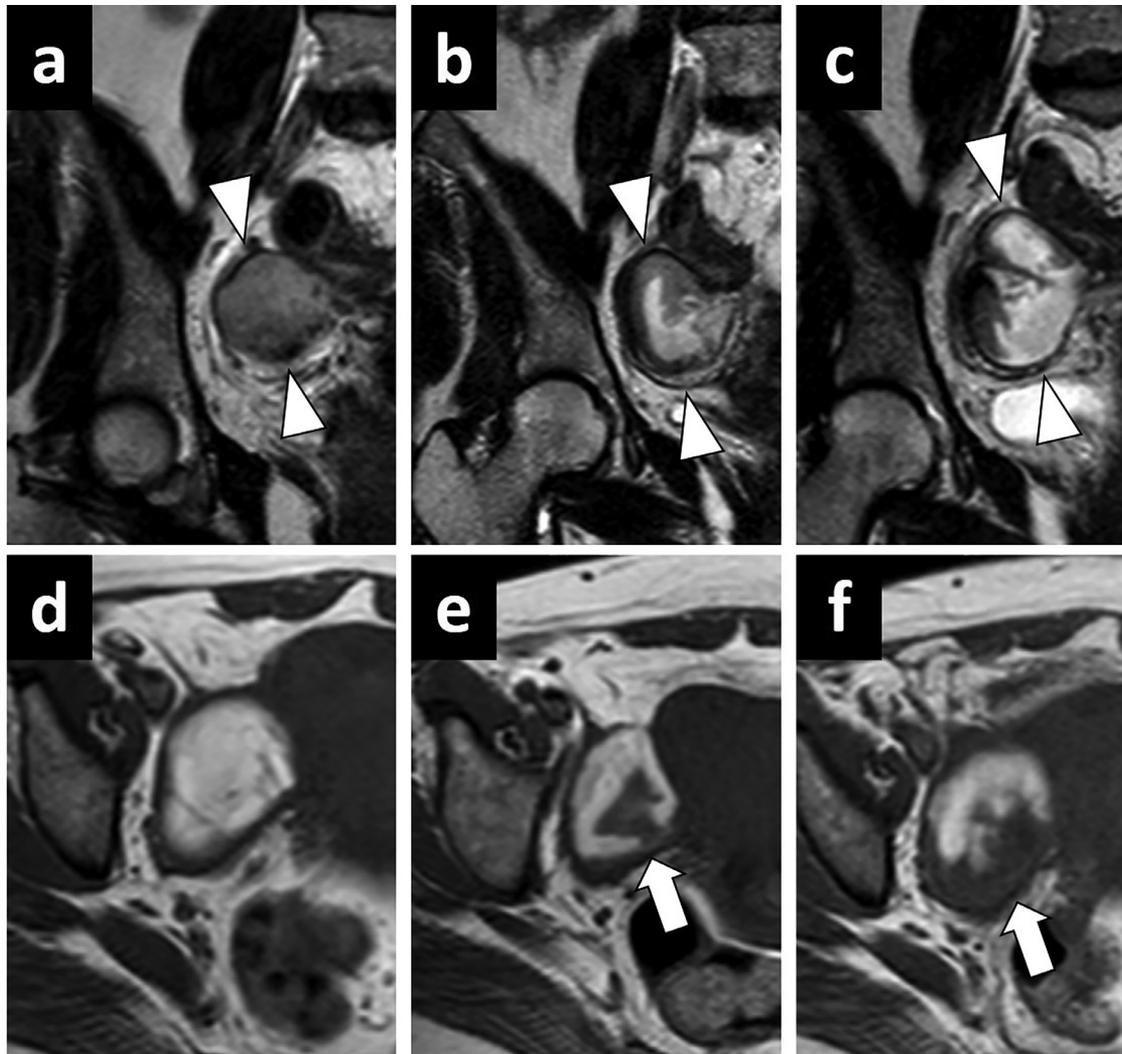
Temporal evolution of right-sided infected endometrioma. (A–C) Coronal plane T2W images of baseline MRI 6 months before the admission (A), MRI at the time of admission (B), and follow-up MRI on day 11 after admission (C) demonstrate progressive «disappearance of T2 shading» and a considerable increase in lesion size (arrowheads, A, B, and C). (D–F) Axial plane T1W images of baseline MRI 6 months before the admission (D), MRI at the time of admission (E), and follow-up MRI on day 11 after admission (F) demonstrate focal and progressive «T1 signal reversal» within the endometrioma (arrows, E and F).
